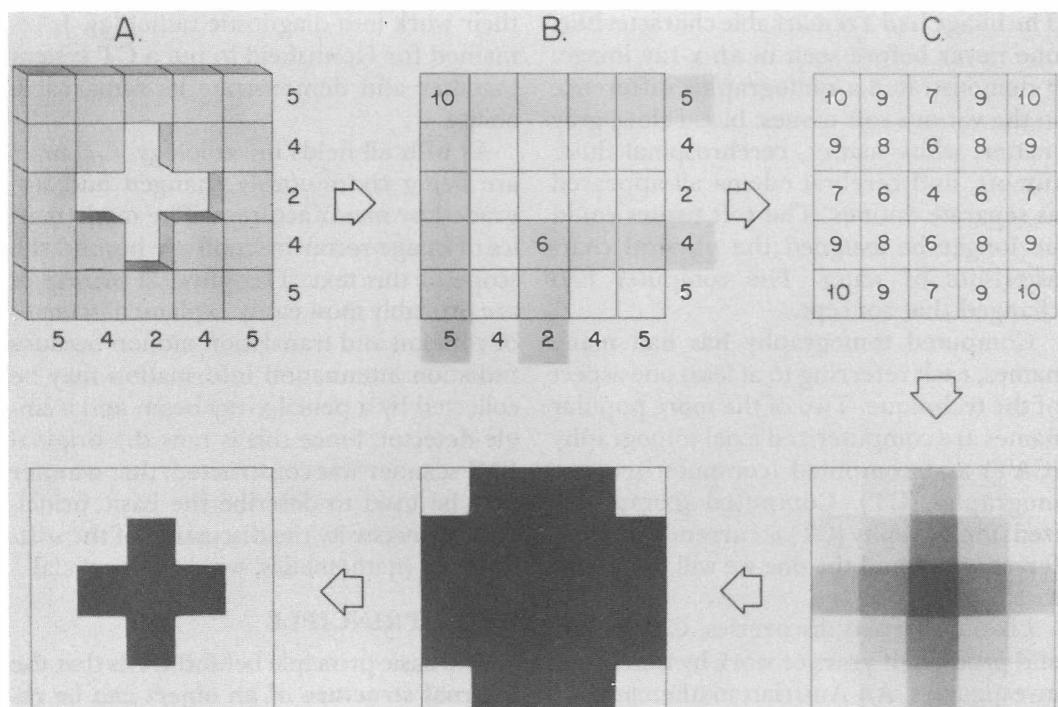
The basic principle of computed tomography
